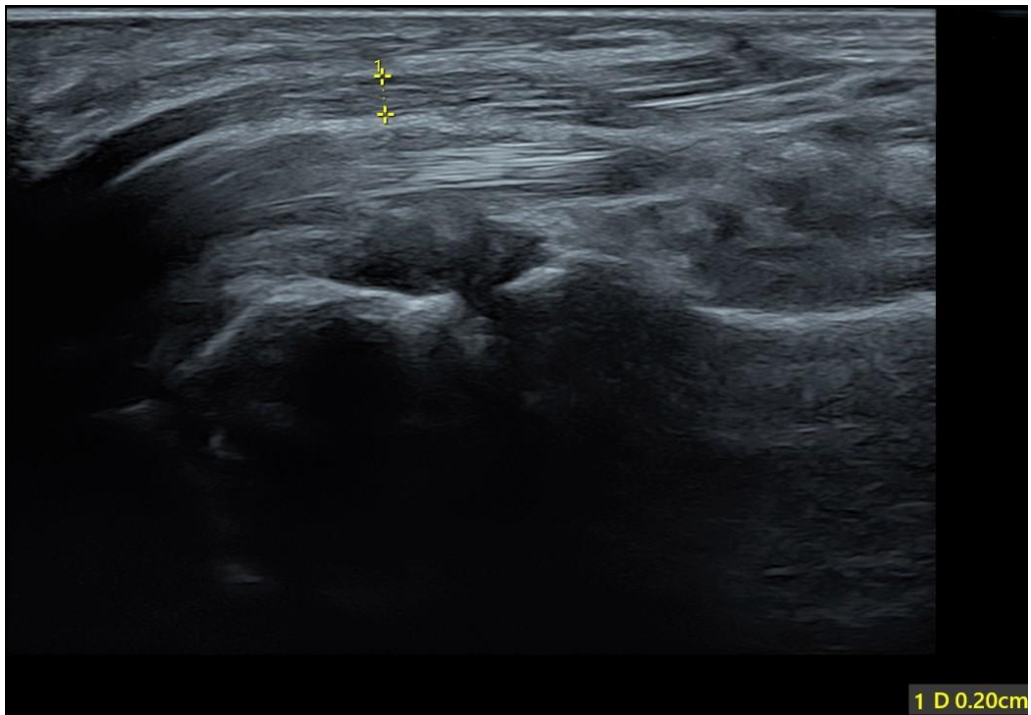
Ultrasound grey scale image, longitudinal section showing AP thickness of median nerve - 2.0 mm in a diabetic patient with neuropathy
